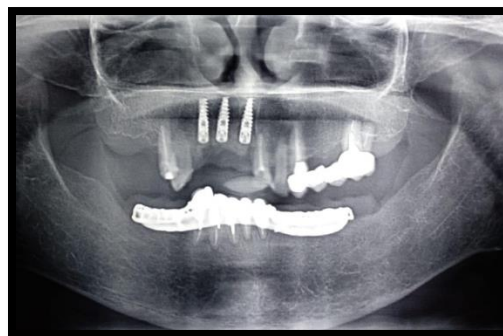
Post implantation Radiograph.
